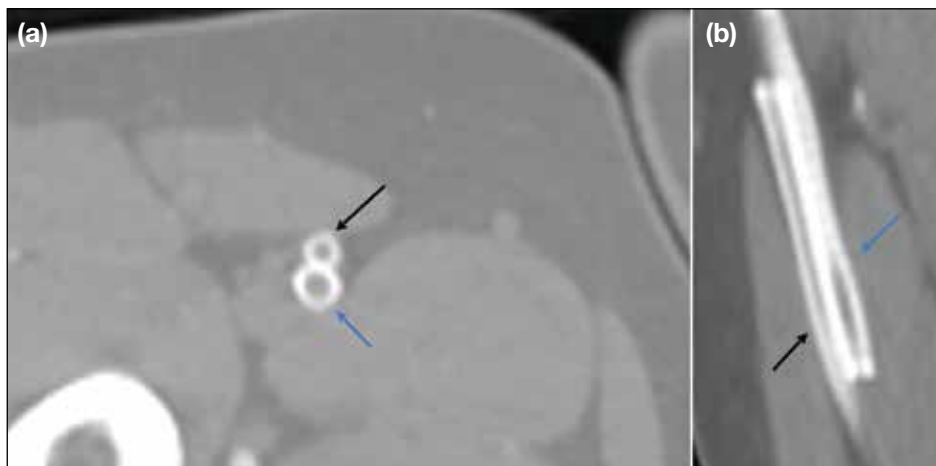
Computed tomography angiogram in 2022 showing stent occlusion, likely resulting from malalignment of the common femoral artery to the Supera stent (blue arrows) of the proximal superficial femoral artery (CFA-pSFA) and the Zilver stent (black arrows) of the mid superficial femoral artery (mid-SFA). The distal margin of the CFA-pSFA stent is seen within the subintimal space, external to the mid-SFA stent. (a) Axial view. (b) Sagittal reconstruction.
